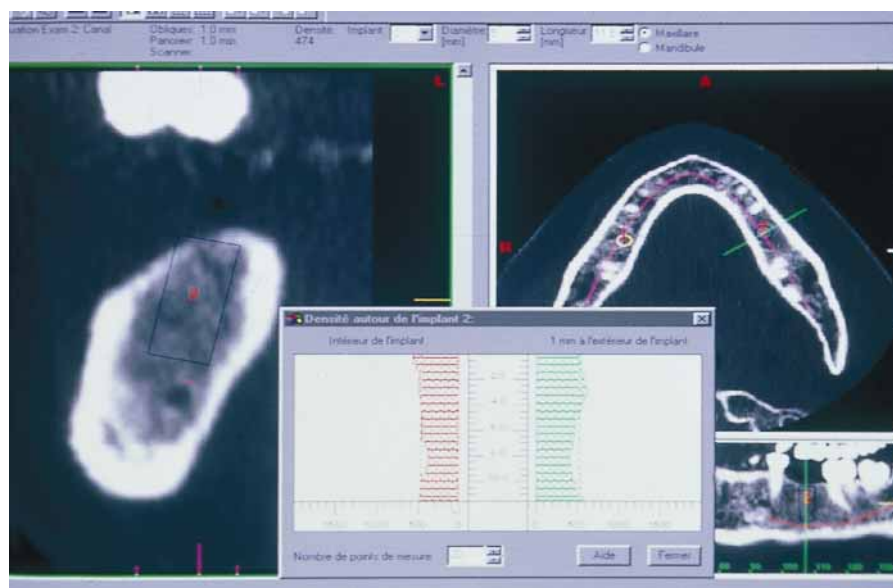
Bone density could be evaluated on new CT scan software.
